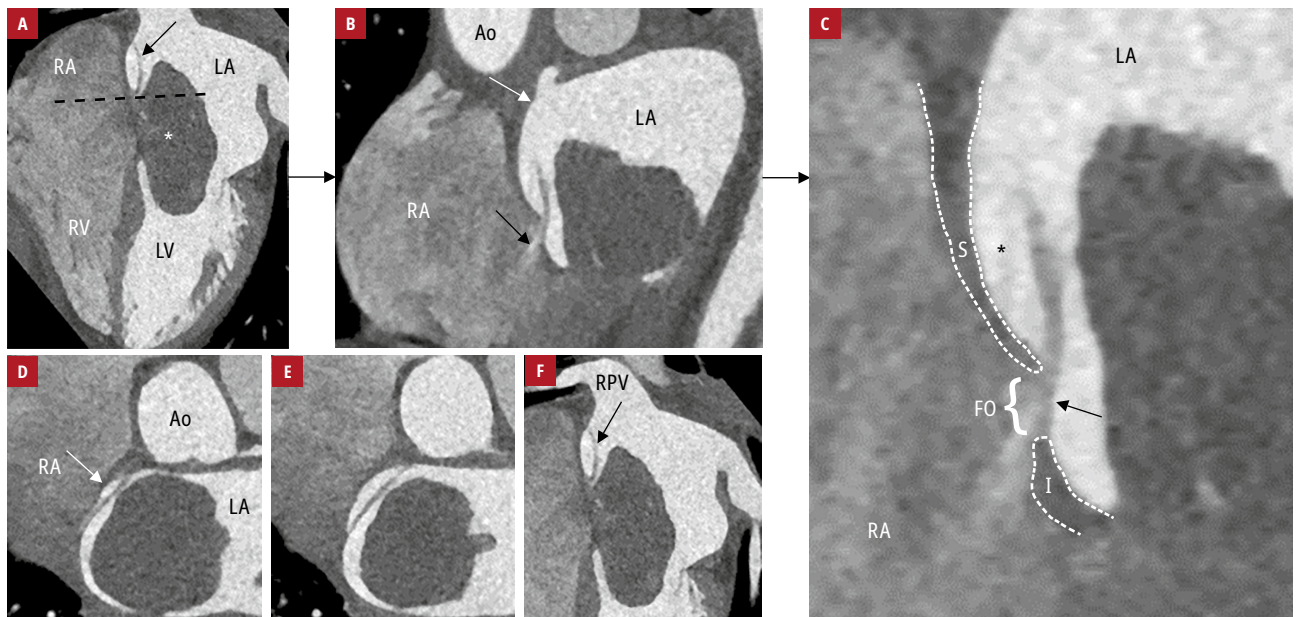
Computed tomography scans: A – a 4-chamber view demonstrating myxoma (asterisk) and flap valve (black arrow); B – a short-axis image obtained at the level of the foramen ovale (dashed line in panel A) demonstrating a shunt (black arrow) and diverticulum (white arrow); C – a magnified image showing the septum secundum (dashed line) and septum primum (arrow) fused to the inferior rim (I) of the fossa ovalis (FO), extending superiorly as a flap and forming a cone-shaped pocket (asterisk). A short-axis image perpendicular to the cone-shaped pocket shows its fundus (D) and superior margin (E). F – disturbed blood flow from the right pulmonary vein along the interatrial septum.
